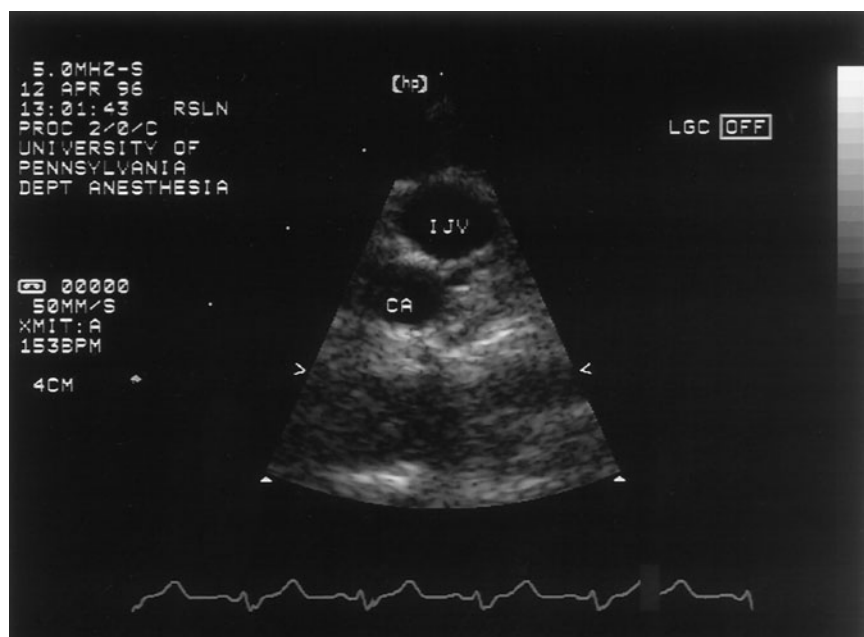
A two-dimensional short-axis image of the internal jugular vein (IJV) and carotid artery (CA) using a handheld ultrasound transducer.
